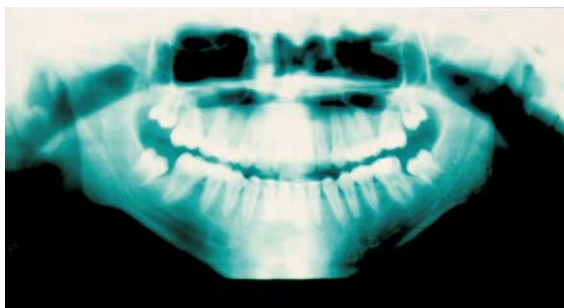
Post-treatment panoramic radiograph showing complete closure of extraction sites and the sufficient space available for the eruption of third molars Case B.
